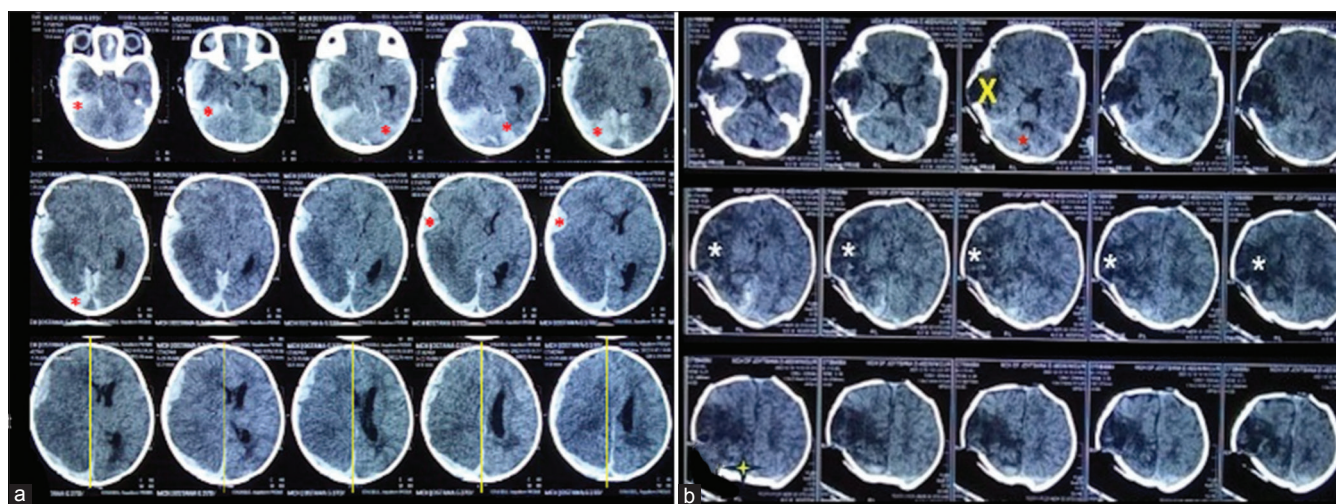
(a) Non-contrast computed tomography (NCCT) brain before surgery showing subdural hemorrhage with mass effect and midline shift of 13 mm as indicated by red asterisk. (b) NCCT brain post-surgery day of life 50. The yellow cross mark represents the status post decompressive craniotomy with pneumocephalus. White asterisk *represents diffuse cerebral edema persisting. *A red asterisk marks the occipital cerebral necrosis.
